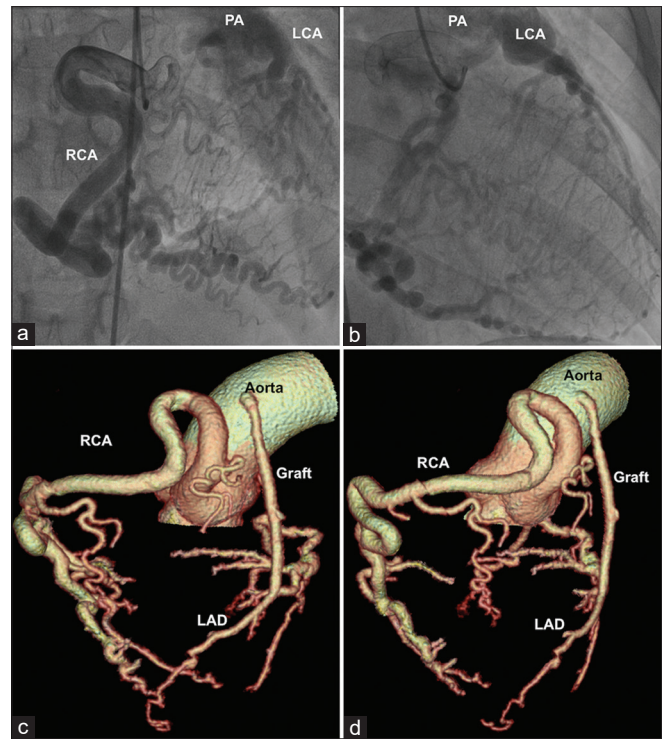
Coronary angiography (a and b) show aneurysmally dilated RCA and late filling of PA trunk through the LCA. Six years later, surveillance computed tomography (c and d) showed persistent aneurysmal RCA dilatation and patent venous graft to LAD artery, necessitating continuation of aspirin and rivaroxaban. RCA: Right coronary artery, PA: Pulmonary artery, LCA: left coronary artery, LAD: Left anterior descending
